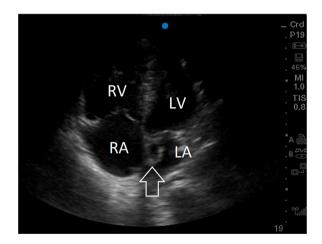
Still image of the apical 4 chamber view shows a severely dilated right ventricle which is larger than the left ventricle with an arrow highlighting a hyperechoic structure extending from the interatrial septum into the left atrium. RV = Right ventricle. RA = Right Atrium. LV = Left Ventricle. LA = Left Atrium.
